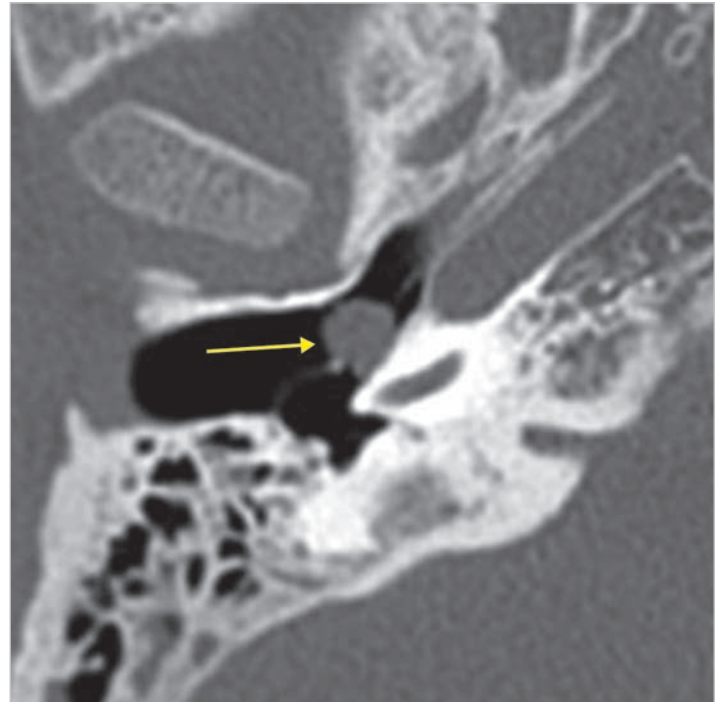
CT scan of the right ear of the same patient, axial view. The cholesteatoma is in contact with the promontorium (arrow).
